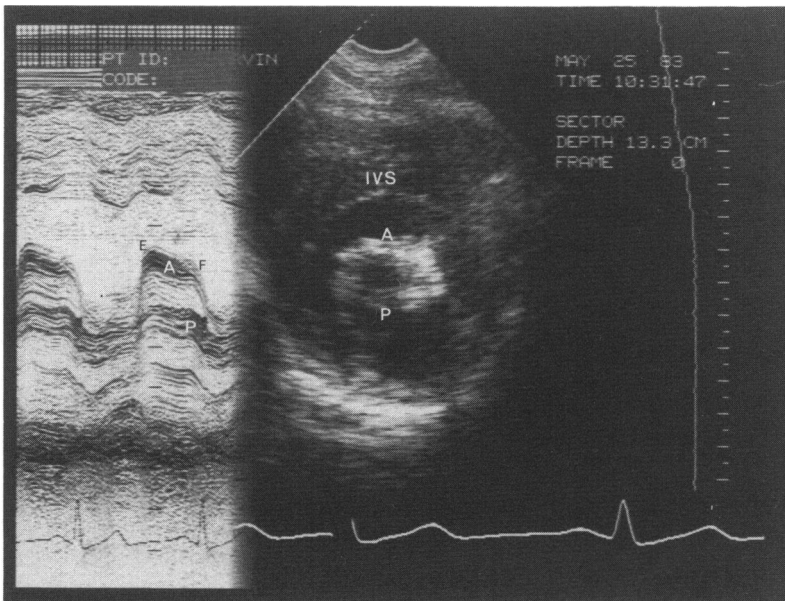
Mitral stenosis. The right figure demonstrates a narrowed orifice of a calcified mitral valve. The orifice is diminished. On the left, the M-mode echocardiogram shows the thickened anterior and posterior leaflets of the mitral valve and a decreased E-F slope due to the obstruction to inflow of blood into the left ventricle due to the mitral stenosis.
